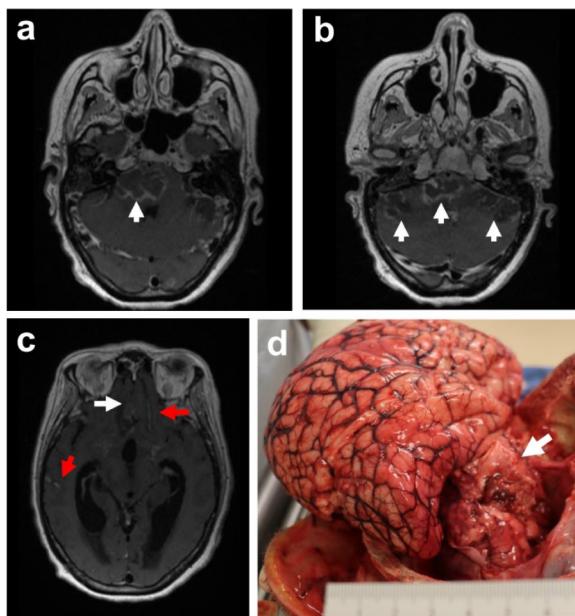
Follow-up MRI findings and gross brain at postmortem examination. Axial post-contrast T1-weighted MRI performed on day 29 of hospitalization showed a expansion of the initial pontine lesion (arrow) with b new brainstem (arrow) and cerebellar lesions (arrows) as well as c cerebral (white arrow) and leptomeningeal (red arrows) lesions. d Brain at autopsy with cerebral edema, cerebellar herniation, hemorrhage, and brainstem necrosis (arrow)
